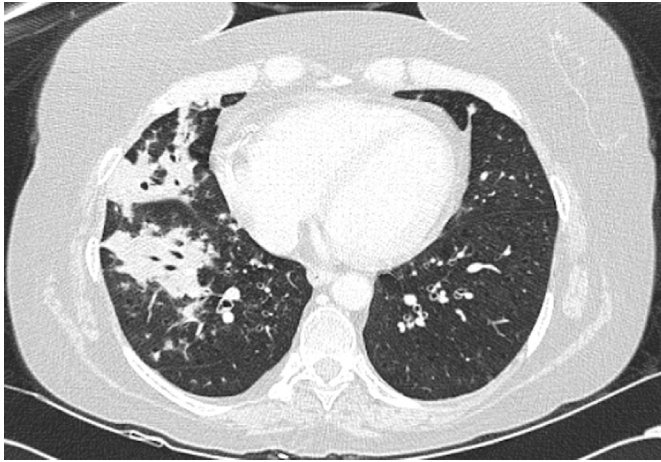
Axial CT of the chest with contrast showing confluent consolidation within the right lower lobe.
